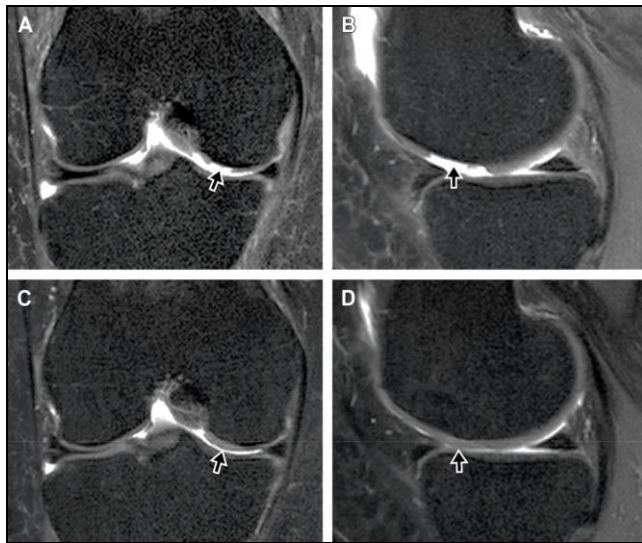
MRI slides of Grade II osteoarthritis knee patients Image A and B shows the coronal and sagittal section of MRI images of pre-procedure fat saturated proton density of right knee of a 50-year-old female patient having grade II osteoarthritis knee. In it cartilage loss in medial femoral condyle was observed. (arrows). Image C and D shows the coronal and sagittal section of MRI images of 48 weeks post-procedure fat saturated proton density of right knee of the same above patient. Complete filling of the defect along with complete integration with the adjacent native tissue/cartilage of was observed (arrows).
